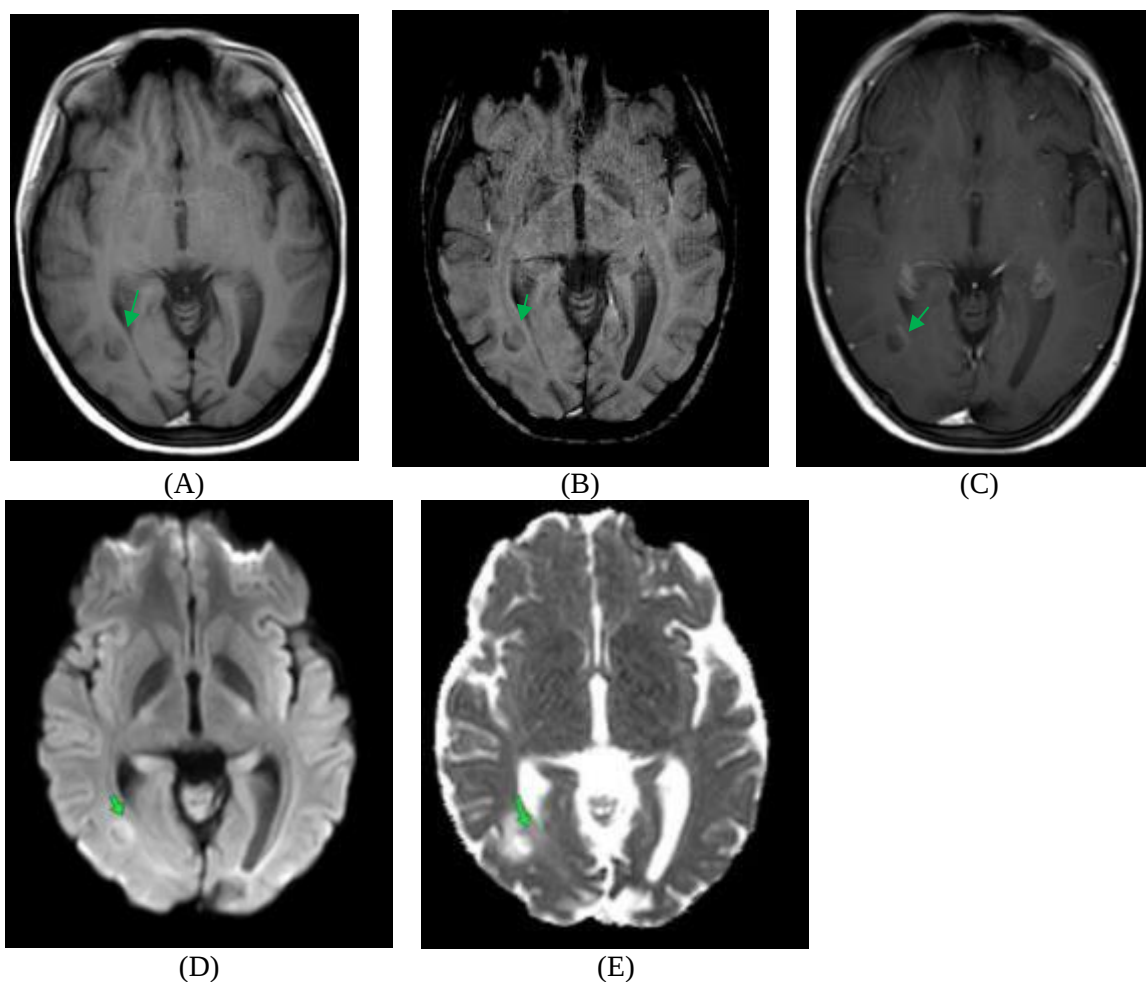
A) periventricular lesion (green arrow) demonstrated a rim of susceptibility on SWI. B) T1 Pre-contrast axial cut of the lesion. C) A rim of enhancement was seen on post contrast T1 of the same lesion. D) This rim also corresponded to high signal on DWI. E) Low signal on ADC map represented diffusion restriction.
